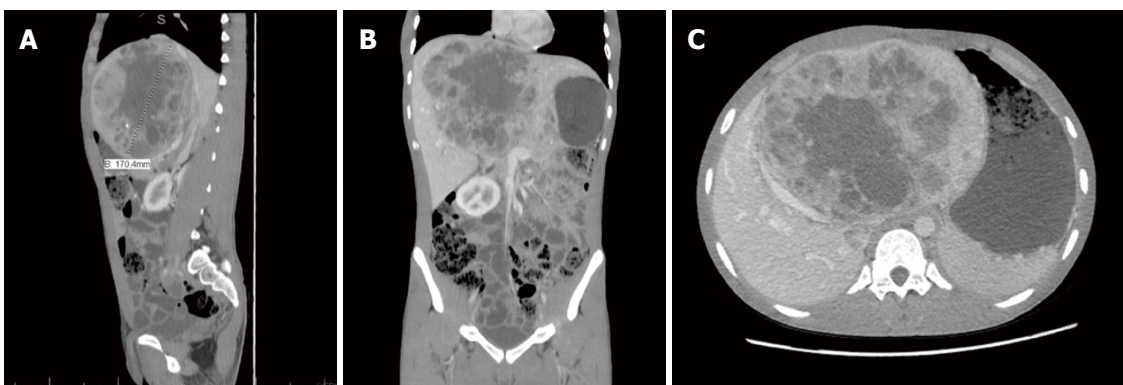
The computed tomography of hepatic lesion. A and B: Computed tomography showing a voluminous heterogeneous hepatic lesion, with a neoplastic aspect and dimensions 19.5 cm × 12.5 cm × 17.0 cm; C: Compression of the right hepatic vein.
